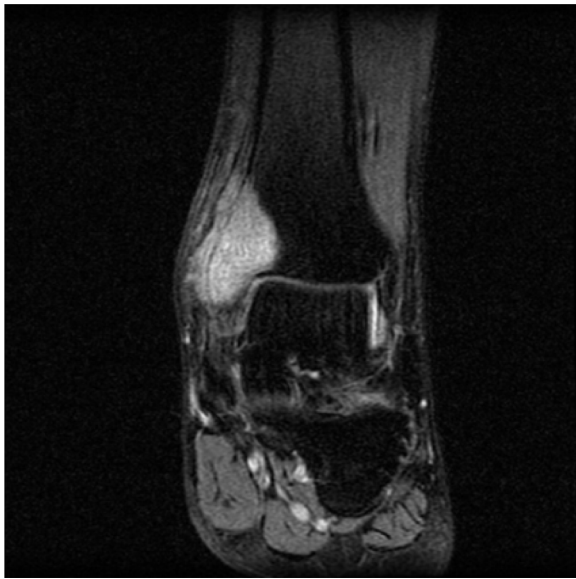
The first MRI of the left ankle showing osteomyelitis of the left fibula.
